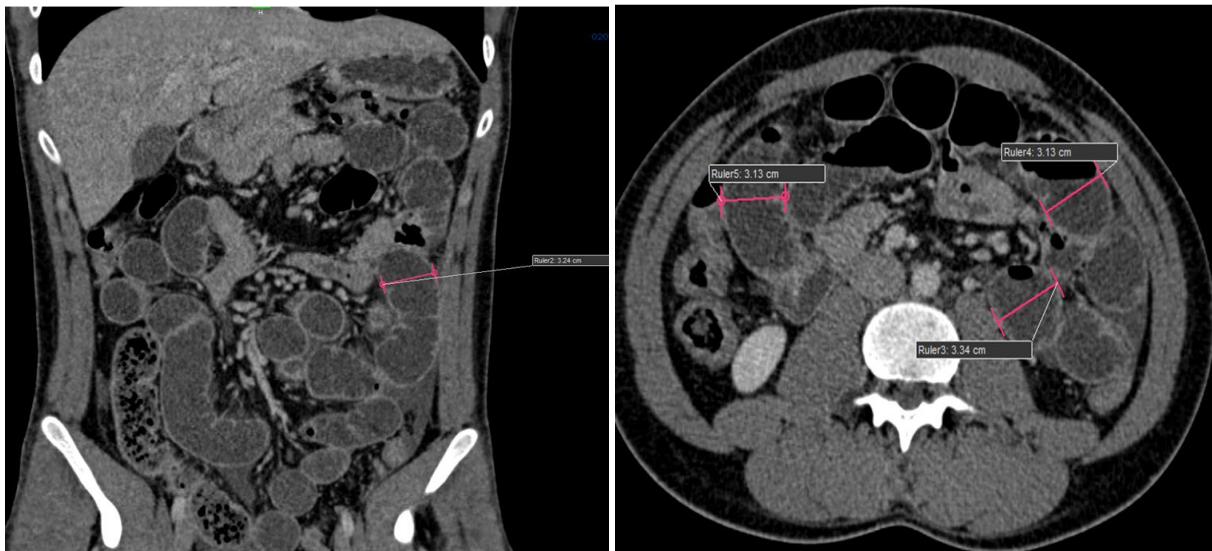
Contrast-enhanced CT of the abdomen shows multiple dilated small bowel loops
